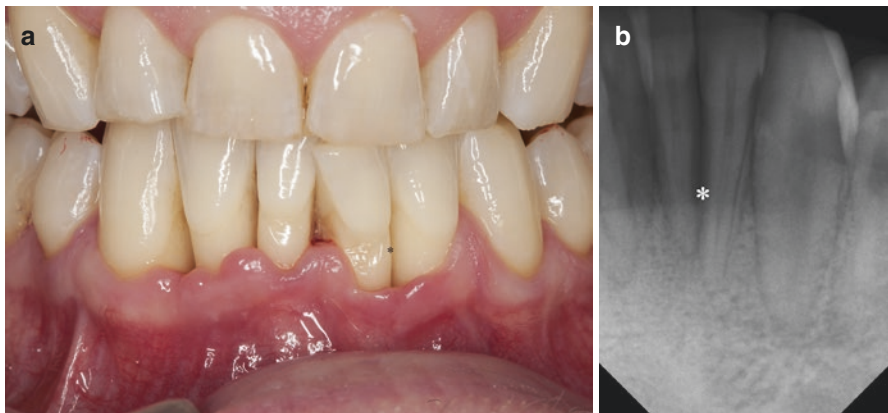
(a) Buccal position/rotation of #31, root proximity #31/32, interdental and buccal recessions up to 5 mm in 5th sextant, PPD up to 5 mm, CAL up to 10 mm (#31); (b) periapical radiograph of #31/21 with bone loss of more than 2/3 of the root length
